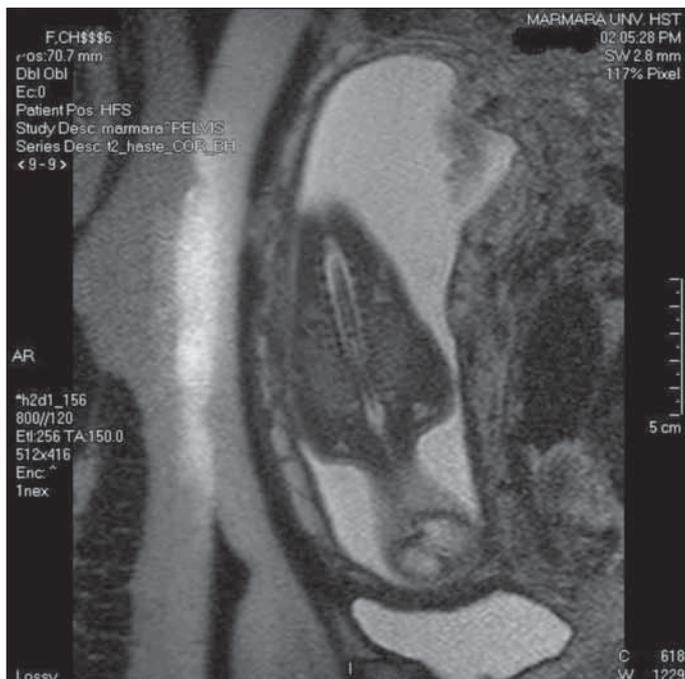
MRI of the fetal spine in Case 2. Two hemicords are seen separately ending as a single conus medullaris
